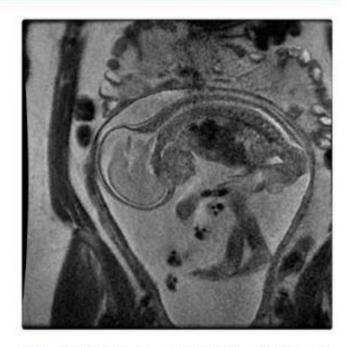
MRI at 20 weeks - sagittal section of fetus depicts micrognathia with other structures appearing normal.
